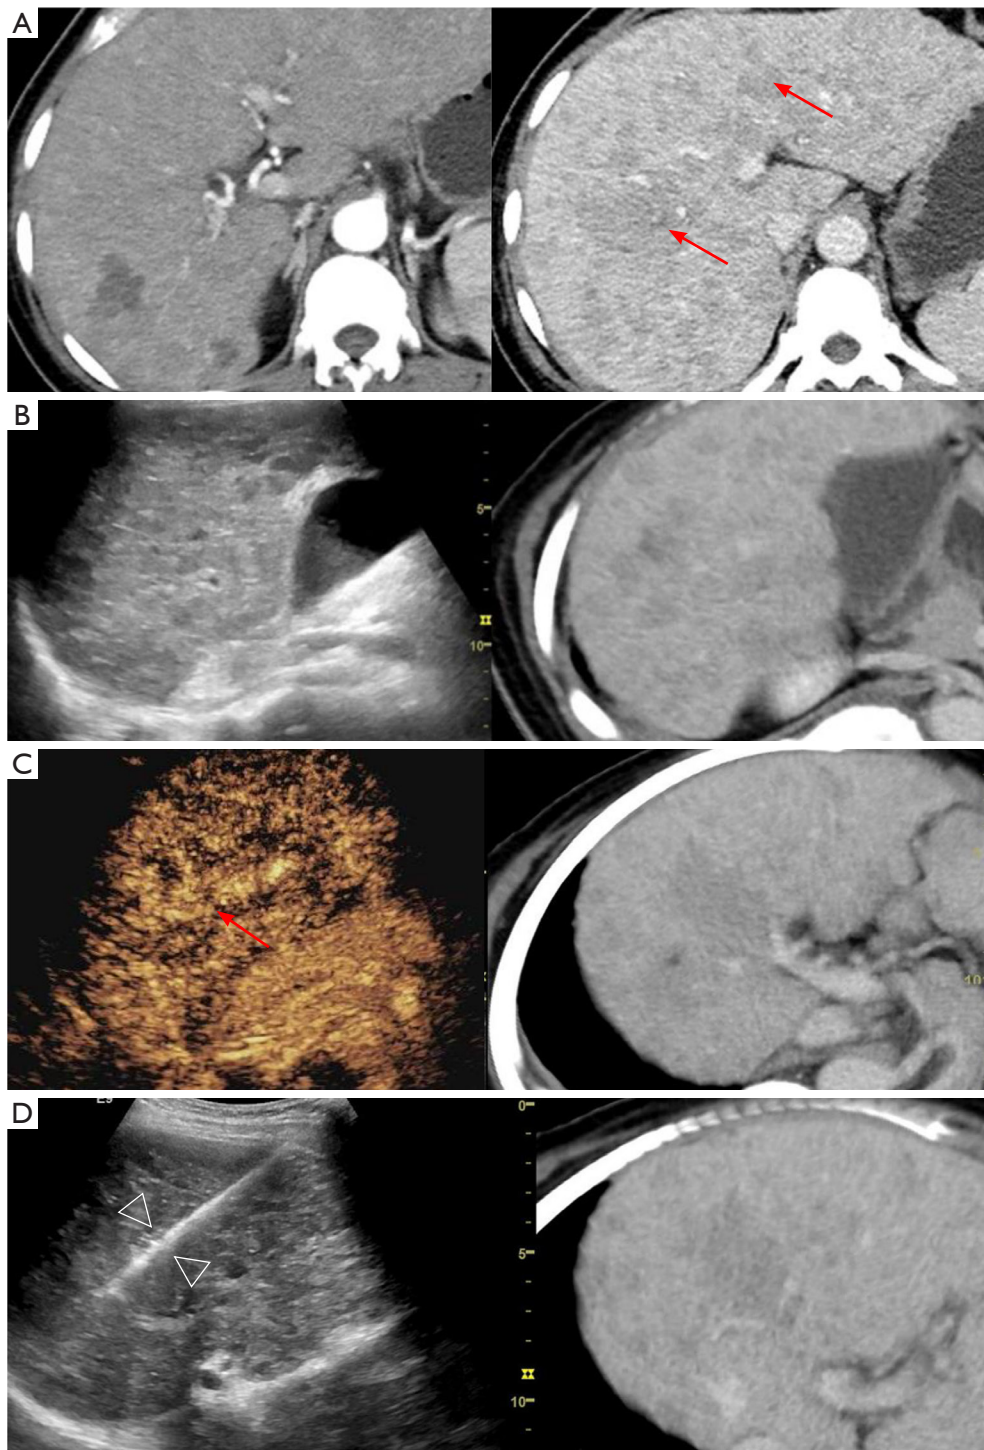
A 41-year-old female with HCC and bone metastasis. (A) Diffusely distributed masses revealed by contrast-enhanced computed tomography (red arrows: infiltrative HCCs). (B) Multiple heterogeneous hyperechoic zones with unclear boundaries on B-mode ultrasound fusion. (C) Masses with partial hyperenhancement identified in the artery phase of contrast-enhanced ultrasound fusion (red arrow: infiltrative HCCs). (D) B-mode ultrasound fusion-guided biopsy (white arrowheads: biopsy needle). HCC, hepatocellular carcinoma.
